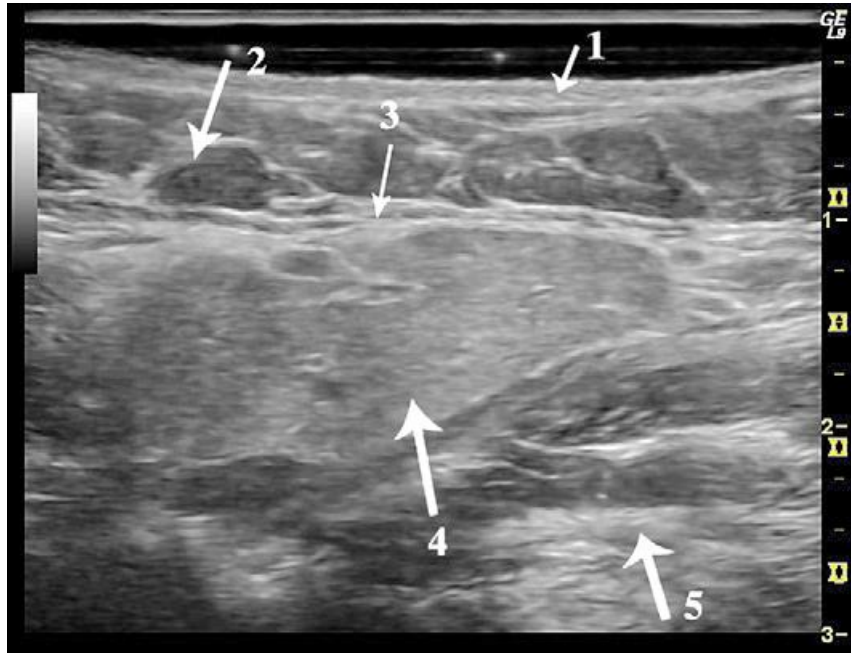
Transverse sonogram of right normal submandibular gland. 1: skin, 2: fat, 3: fascia, 4:parenchyma, 5: mylohyoid muscle. (Philips Katz et al.)
